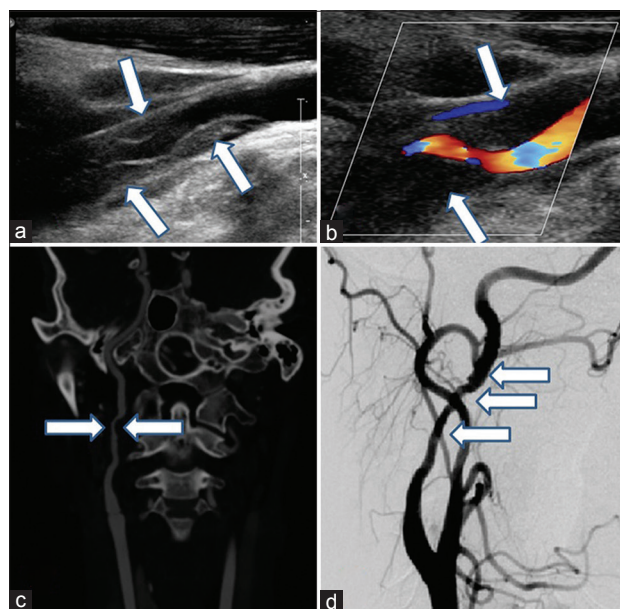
The manifestation of internal carotid artery dissection of a 31-year-old female patient. (a) Multiple intramural hematomas (arrows) were showed clearly in the right internal carotid artery by ultrasound. (b) Intramural hematomas (arrows) and the unusual curved bloodstream between them were showed in the left internal carotid artery by ultrasound. (c) The stenosis of the right internal carotid artery (arrows) was showed by computed tomography angiography. (d) Diffused, long-distance corrugated sign (arrows) at the right internal carotid artery was showed by digital subtraction angiography.
